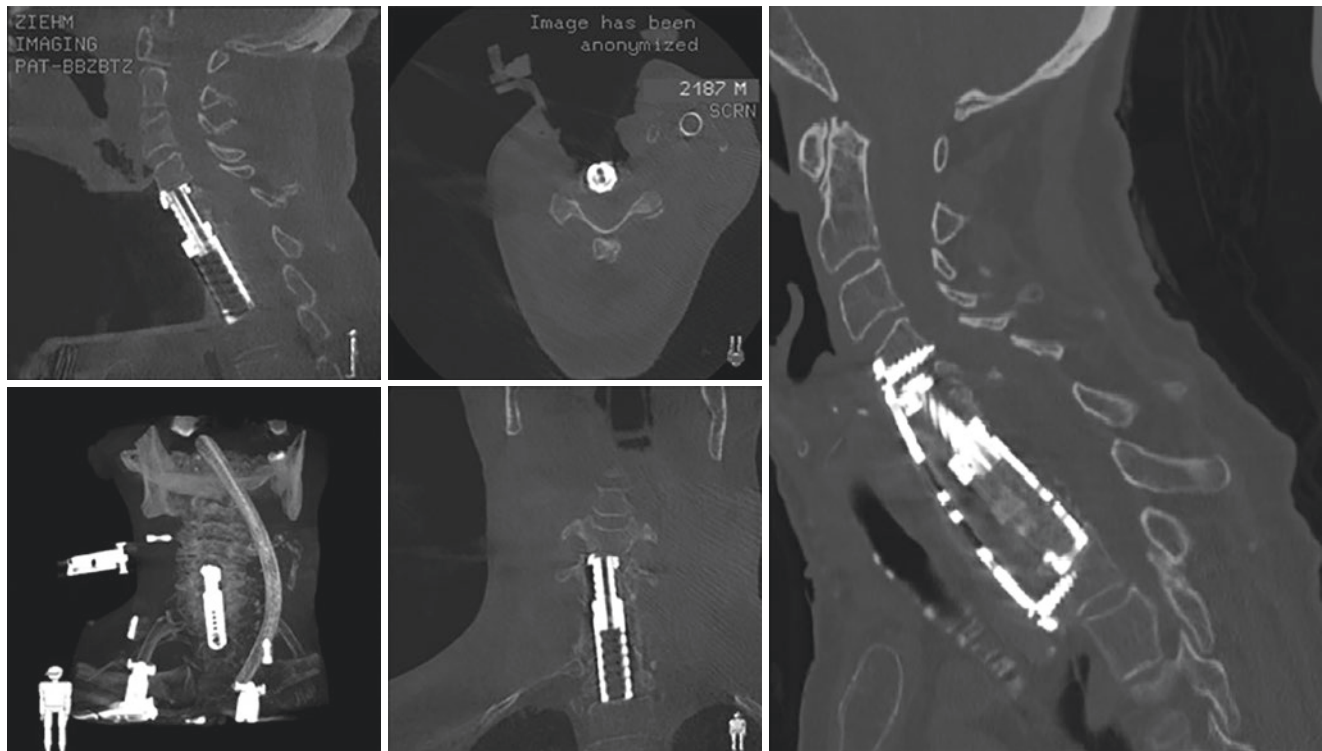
Intraoperative imaging with Ziehm (left) and postoperative CT scan (right) showing a four-level corpectomy (C5, C6, C7, and T1) and plating with an expandable C5-T1 cage
